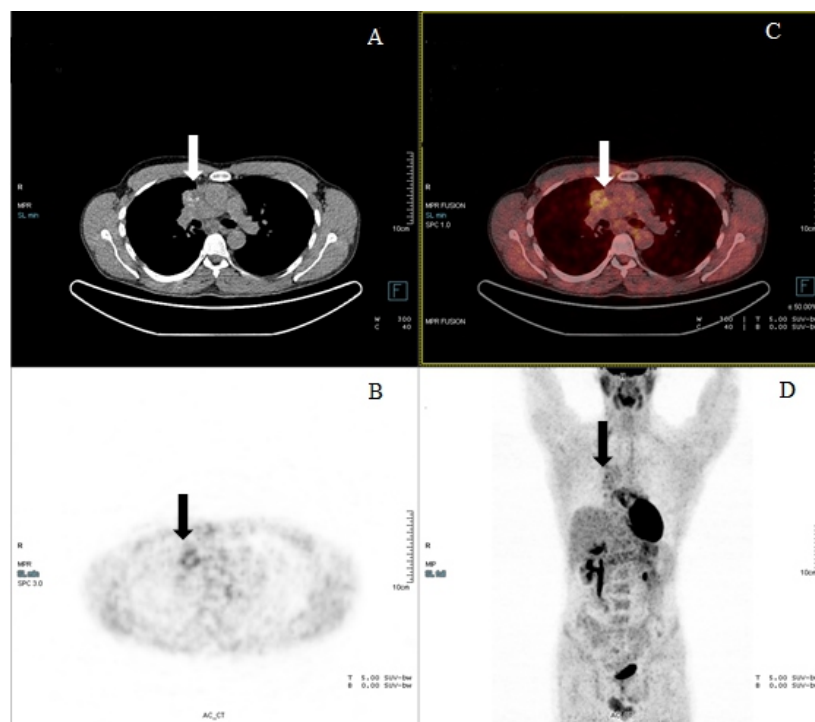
Interim ^{18}F -FDG PET/CT scan in a patient with DLBCL, axial section on non-contrast, low-dose CT (A); PET (B); fusion PET/CT (C) and MIP (D); In which arrows point to a change in the mediastinum with moderately increased ^{18}F -FDG accumulation, with metabolic and morphological regression compared to the initial ^{18}F -FDG PET/CT; DS 3 (shown in Figure 1).
